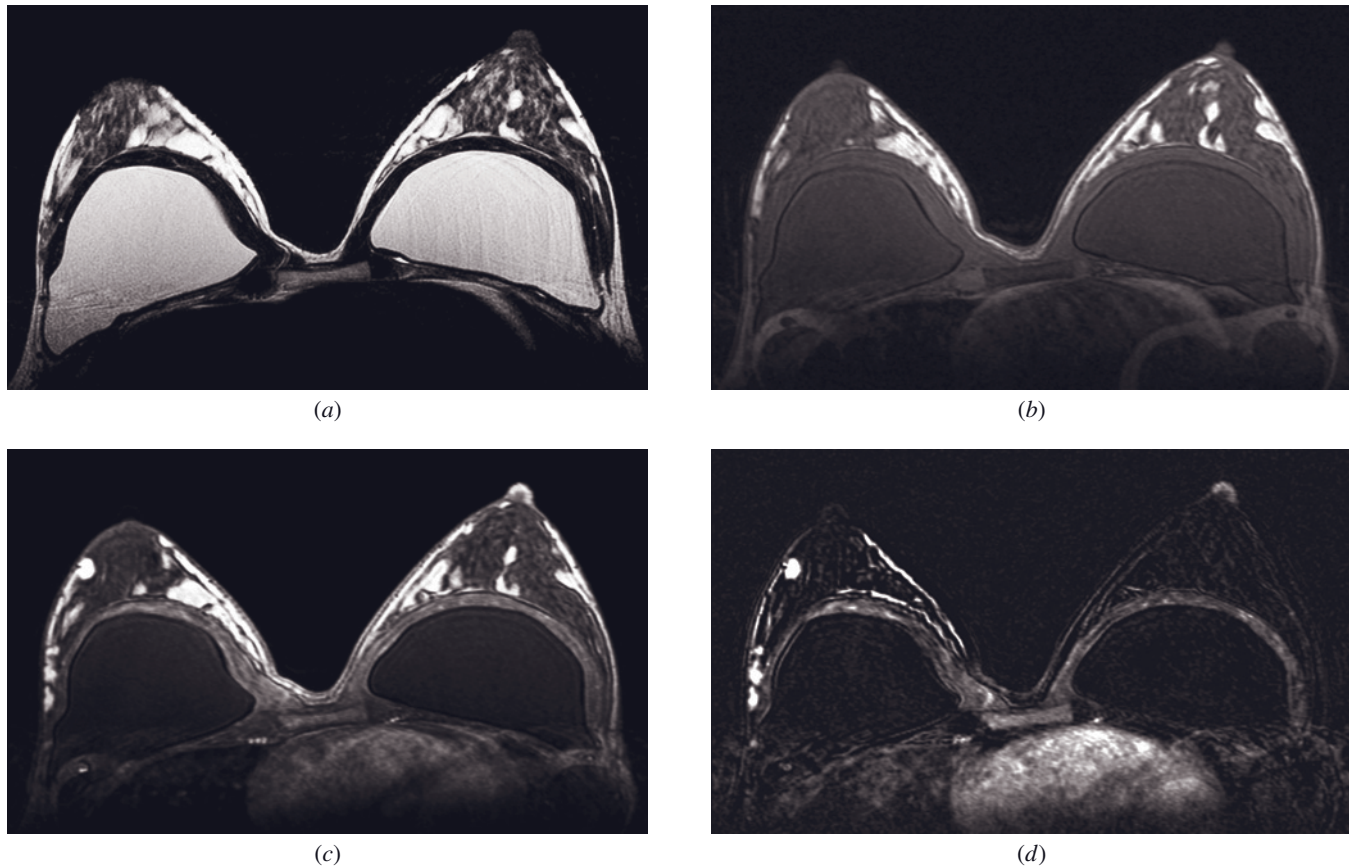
Multifocal IDC in patient with silicone implants. Subpectoral silicone implants are seen on axial T2-weighted (a) and T1-weighted GRE (b) images. Multiple enhancing masses are seen in the lateral aspect of the right breast on postcontrast T1-weighted GRE (c) and subtracted (d) images. Biopsy revealed multifocal IDC (Courtesy of Dragana Bogdanovic-Stojanovic, M.D., Diagnostic Imaging Center, Oncology Institute of Vojvodina, Serbia.)
